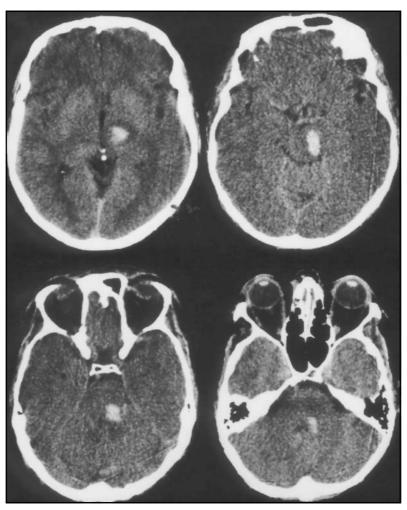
CT scan demonstrated a large hemorrhage area in the brain steam.
